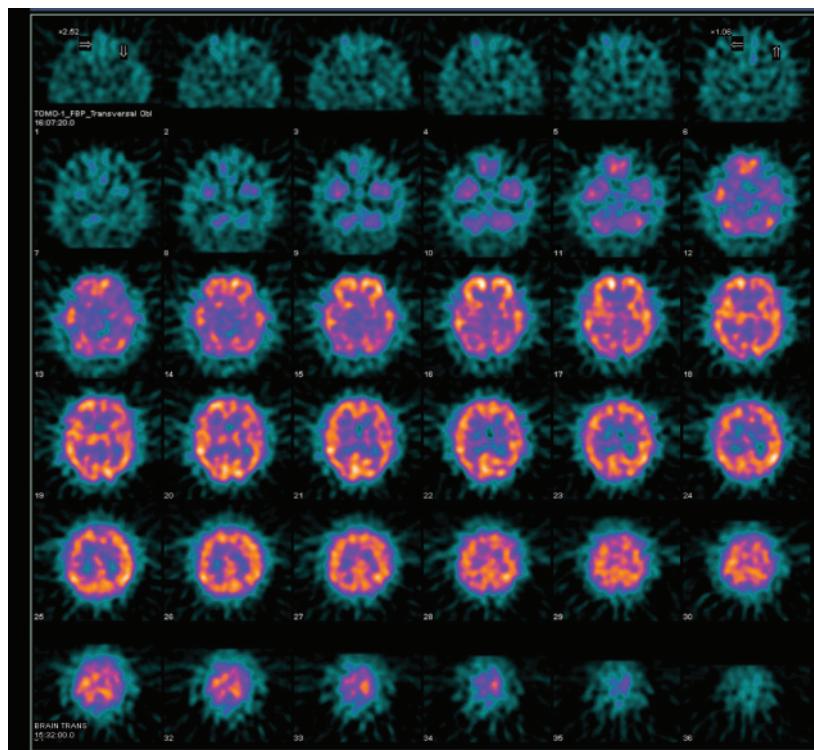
Transversal view of brain SPECT
